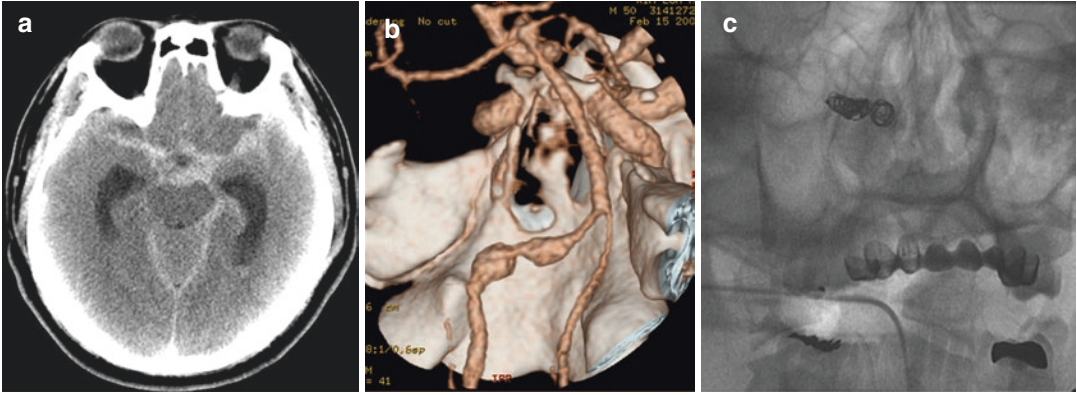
A 45-year-old man developed sudden severe headache after baseball playing. CT showed subarachnoid hemorrhage (a). CT angiogram showed dissecting aneurysm in the left distal vertebral artery (b), which was treated with coil embolization (c)
